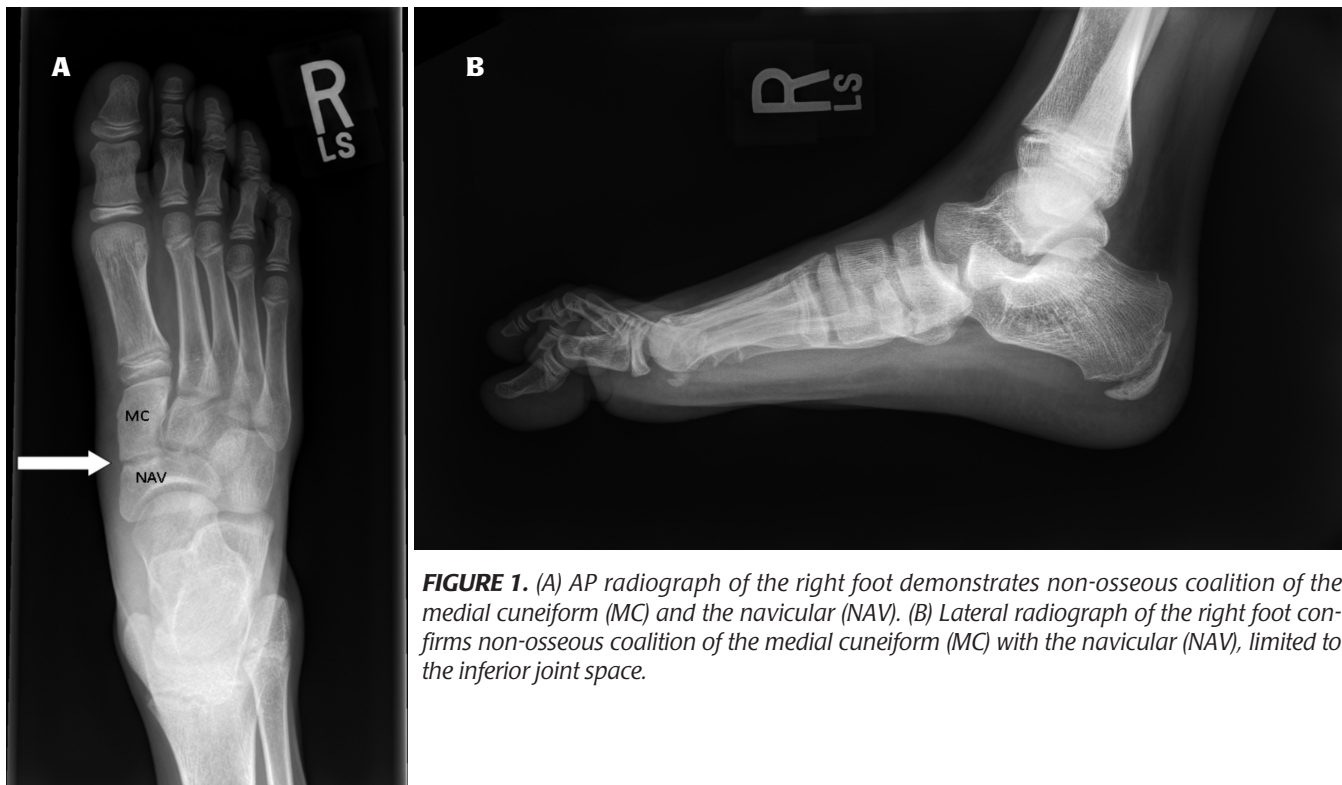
(A) AP radiograph of the right foot demonstrates non-osseous coalition of the medial cuneiform (MC) and the navicular (NAV). (B) Lateral radiograph of the right foot confirms non-osseous coalition of the medial cuneiform (MC) with the navicular (NAV), limited to the inferior joint space.
